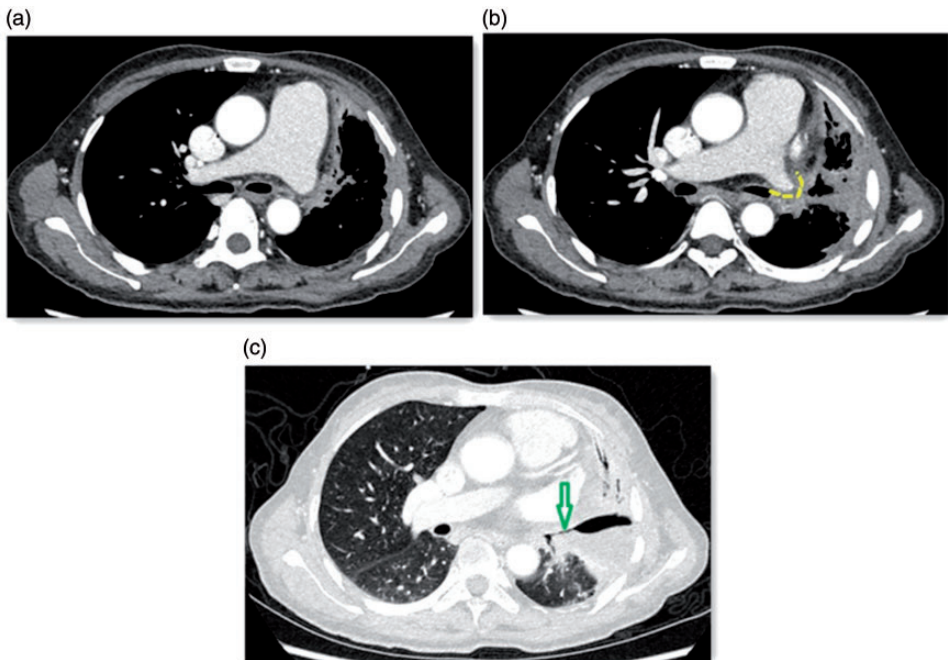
Computed tomographic scan of the chest showing (a) pulmonary artery dilatation with an internal diameter of about 3.7 cm, (b) the Westermark sign (dotted yellow line), and (c) a bronchopleural fistula.
